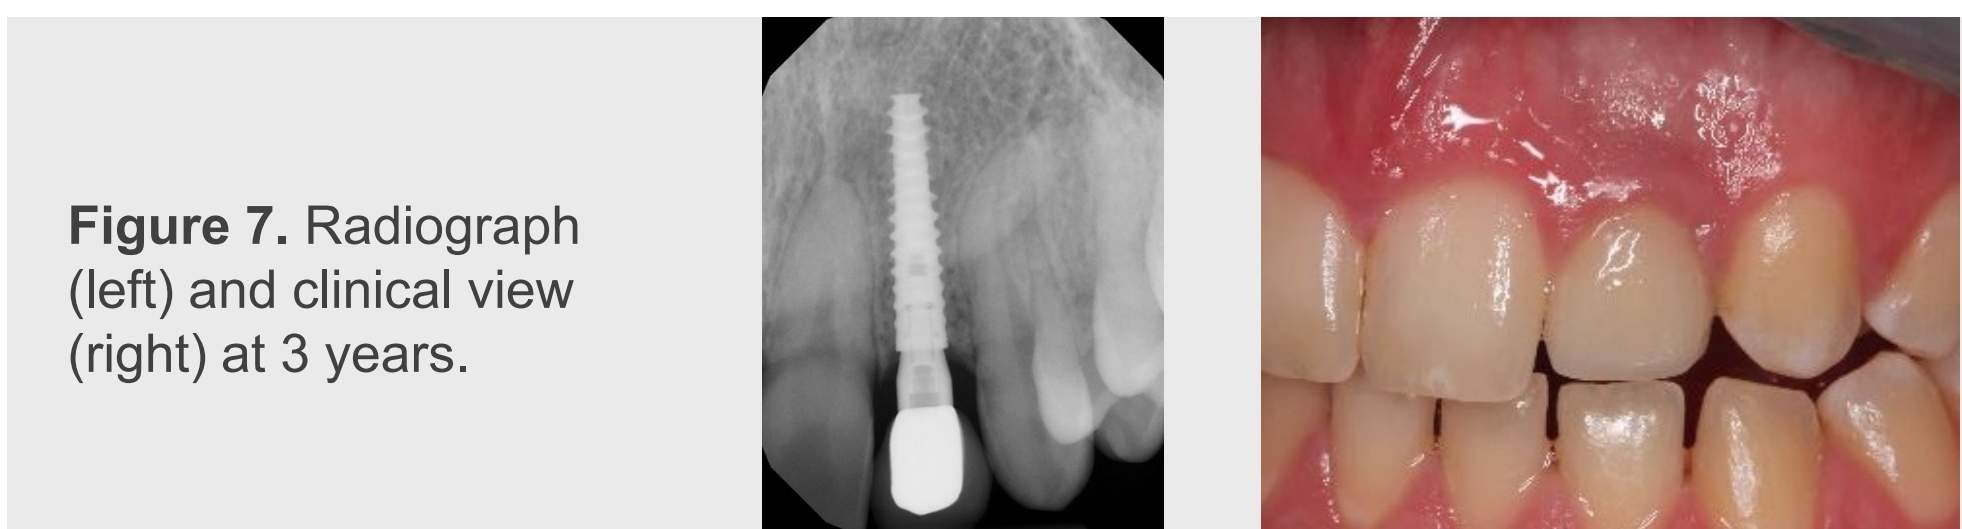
Radiograph (left) and clinical view (right) at 3 years.
